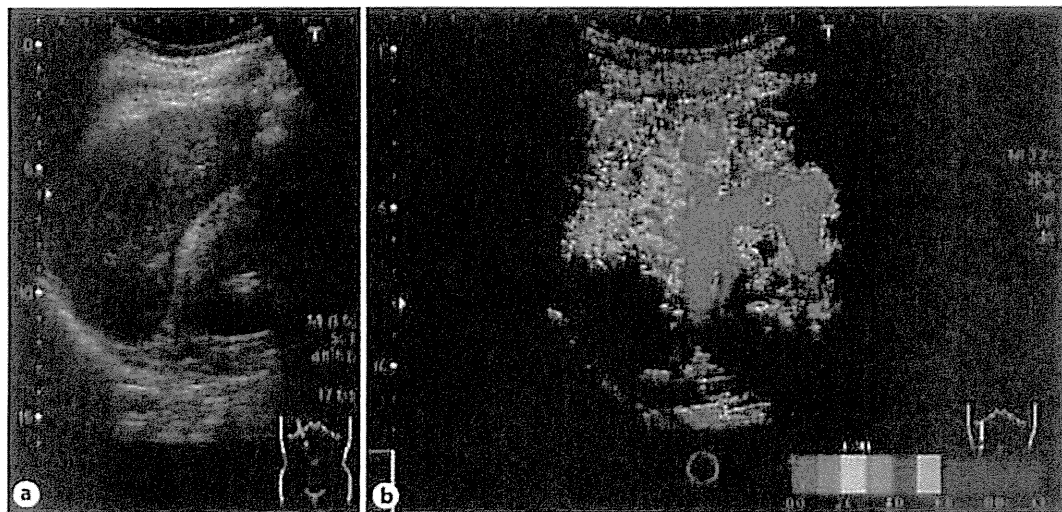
Ultrasound images of case 1 taken in December 2009. a B-mode ultrasound image. b Arrival time parametric image. The red-colored region decreased, while light and dark green-colored regions increased in the entire area of the arrival time parametric image of the liver.
